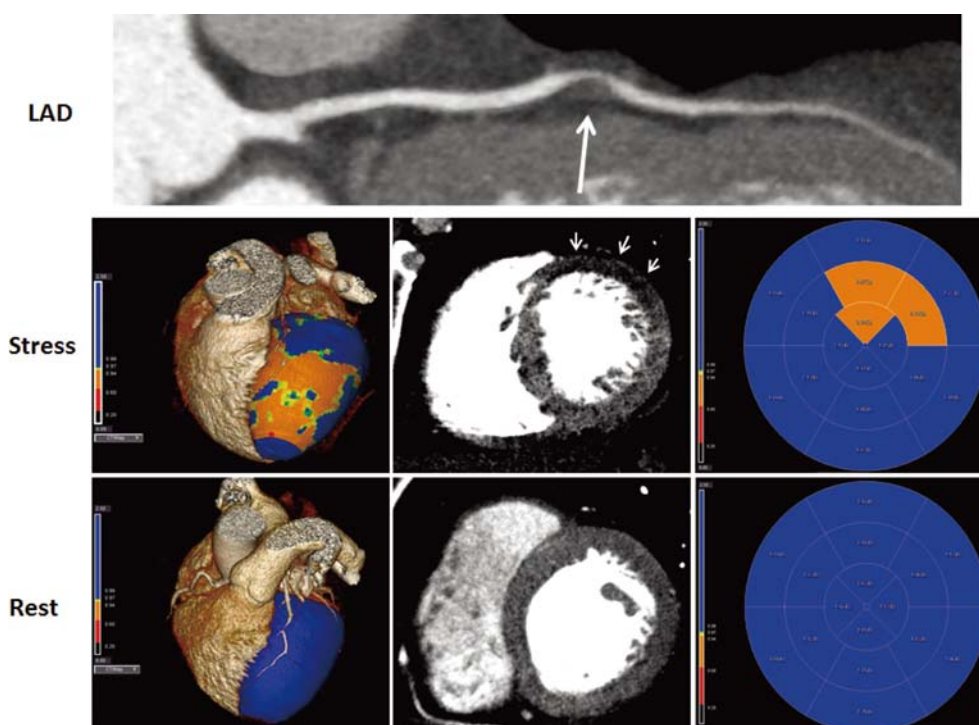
Coronary CTA with CT myocardial perfusion imaging.
